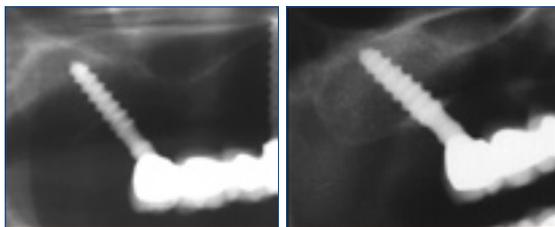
Radiographic detail of tuberosity site 18 in 2000 (same case as Figures 7 and 8).
